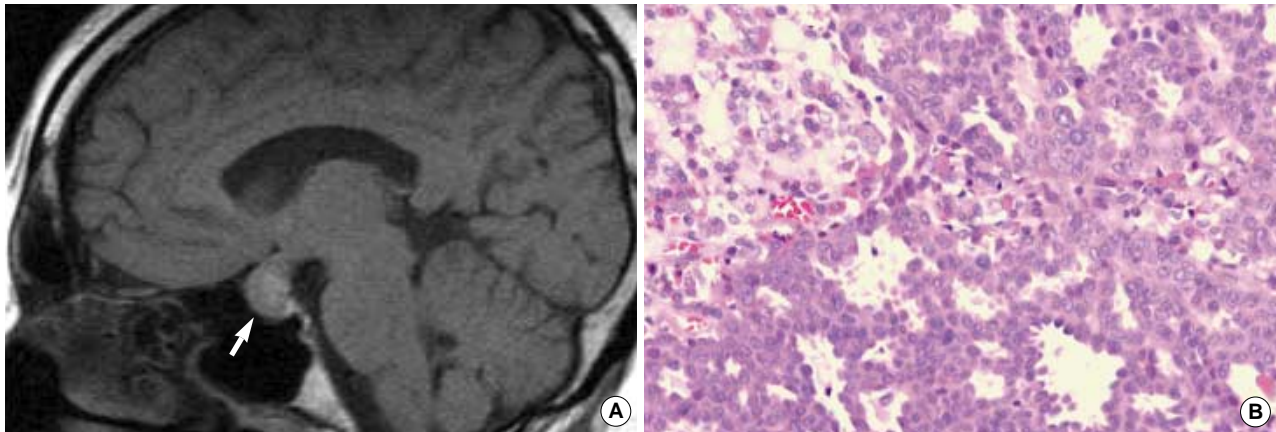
(A) A pituitary mass (arrow) is noted on brain magnetic resonance image taken after a year of follow up. (B) The resected tumor has features of metastatic adenocarcinoma.
